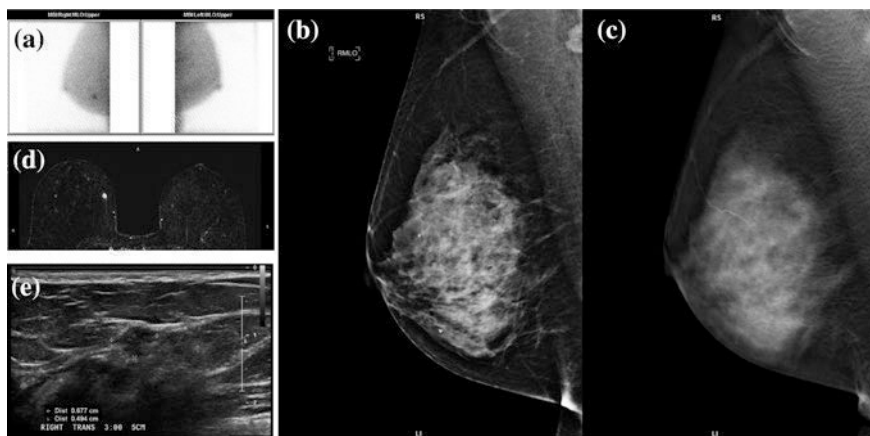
An asymptomatic postmenopausal woman with a prior negative mammogram participated in a research study evaluating the effect of caffeine on Tc99 m sestamibi uptake. Her molecular breast imaging (MBI) exam (bilateral MLO) was positive (a). There was a focal area of moderate intensity radiotracer uptake in the lower inner right breast at middle depth measuring $1 \times 0.7 \times 0.8$ cm. Subsequent digital mammogram (b), and digital breast tomosynthesis (c) showed no correlate to the MBI finding. Breast MRI (d) depicted a $0.6 \times 0.6 \times 0.9$ cm enhancing round mass with slight irregular margins corresponding to the abnormality identified by MBI (a). Second look ultrasound (e) followed by ultrasound guided biopsy indicated a 6 mm invasive ductal carcinoma. *Courtesy of Michael K. O'Connor, Ph.D., Mayo Clinic, Rochester, MN*
